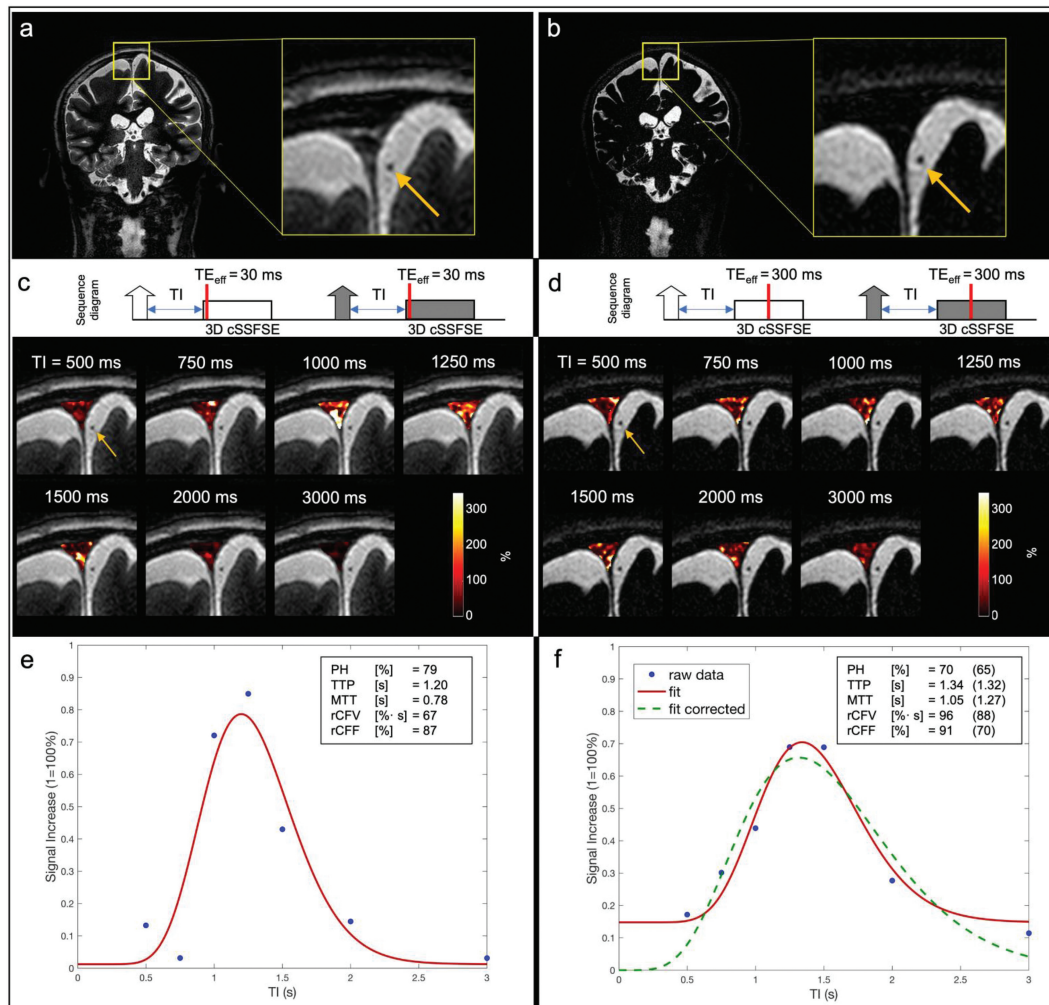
The tag-on and tag-off acquisitions using a TE_{eff} of (a, c, and e) 30 ms and (b, d, and f) 300 ms. (a) and (b) are coronal images and their enlarged anatomic images of TE_{eff} of 30 ms and 300 ms, respectively. (c) and (d) show the acquisition sequence showing the contrast-determined time of TE_{eff} of 30 ms and 300 ms by red line, and their various TI images, respectively. The fusion image with TI 500 ms was used with tagged MRI color images covering the entire SSS region including upper PSD, lower PSD, and SSS at a slice of 3D images using various TI periods. Both TE_{eff} of 30 ms and 300 ms show tagged CSF signals at the upper PSD, lower PSD, and SSS, while showing dark blood signals (yellow arrows) throughout TI periods. Tagged MRI signal curves of both TE_{eff} of (e) 30 ms and (f) 300 ms show similar tagged MRI curves; tagged MRI signal increase (wash-in) and decrease (wash-out) were both around 1100–1300 ms, with similar PH. However, MTT was a bit longer, rCFF and rCFV were higher in data obtained at TE_{eff} of 300 ms, as compared to TE_{eff} of 30 ms. MTT was increased by approximately 270 ms, which is the difference between TE_{eff} of 300 ms and 30 ms. This may be due to adding an extra contrast-determined time of TE_{eff} to the TI period. During the TE_{eff} of 300 ms period, tagged signals within the 3D slab may travel in multiple directions to increase tagged MRI outflow measures. Regarding the baseline of (f) TE_{eff} of 300 ms, it is a non-zero baseline due to the lower signal but higher contrast (more T2-weighted) at TE_{eff} of 300 ms, as compared to TE_{eff} of 30 ms. From the Equation (1), lower signal in the ROI due to the long TE_{eff} is likely to introduce an extra signal bias like a ratio of small signals in both numerator and denominator. To correct this bias, we have added an extra data point (SIR = 0% at TI = 0 ms) based on the assumption that no signal is present at TI = 0 ms. Dotted green line shows the corrected curve fit with zero starting point with the corresponding tagged fluid metrics in the parentheses. CSF, cerebrospinal fluid; MTT, mean transit time; PH, peak height; PSD, parasagittal dura; rCFF, relative CSF flow; rCFV, relative CSF volume; SIR, signal increase ratio; SSS, superior sagittal sinus; TE_{eff} , effective TE; TI, inversion time.
